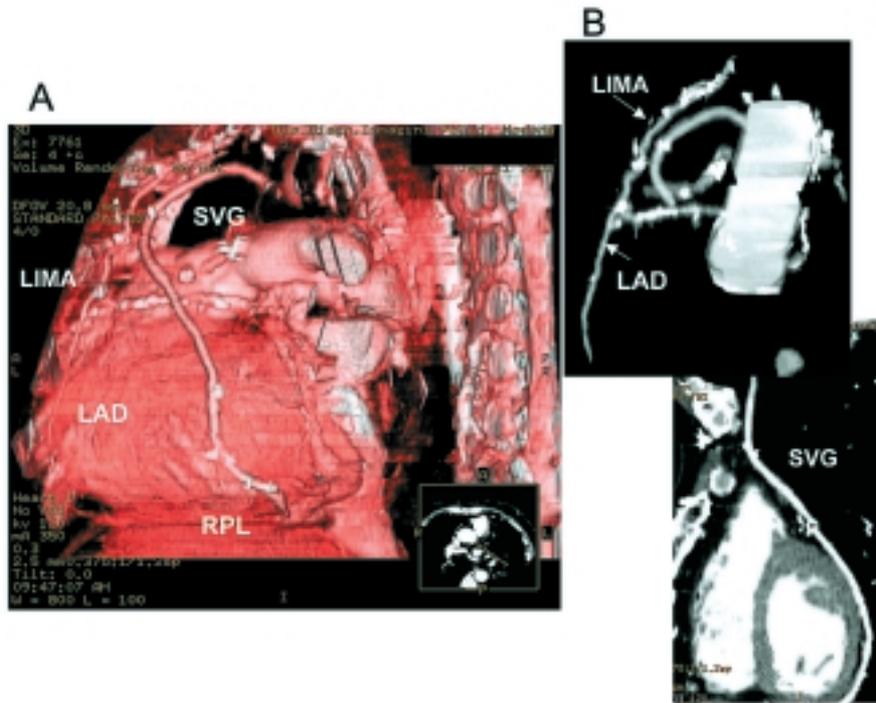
Left posterior oblique volume rendering projection (A) and oblique and curved multiplanar reformat (B) of multislice computed tomography angiography. Patency of both venous and arterial coronary bypass: the left internal mammary artery (LIMA) is anastomosed to the left anterior descending artery (LAD); a saphenous vein graft (SVG) jumps to the postero-lateral branch (RPL).
